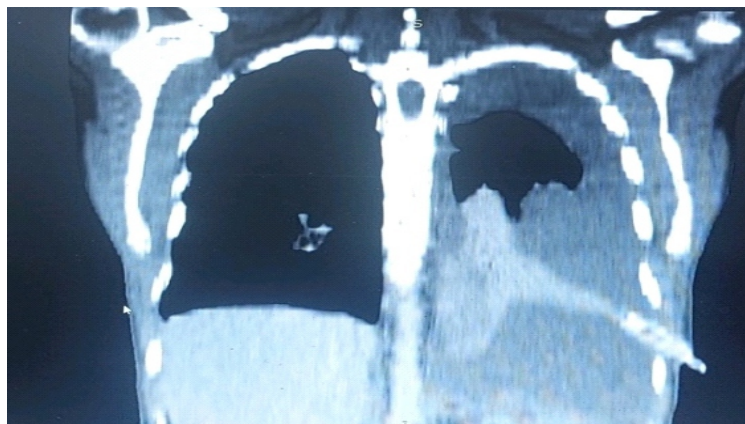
CT chest showing right sided moderate pleural effusion
